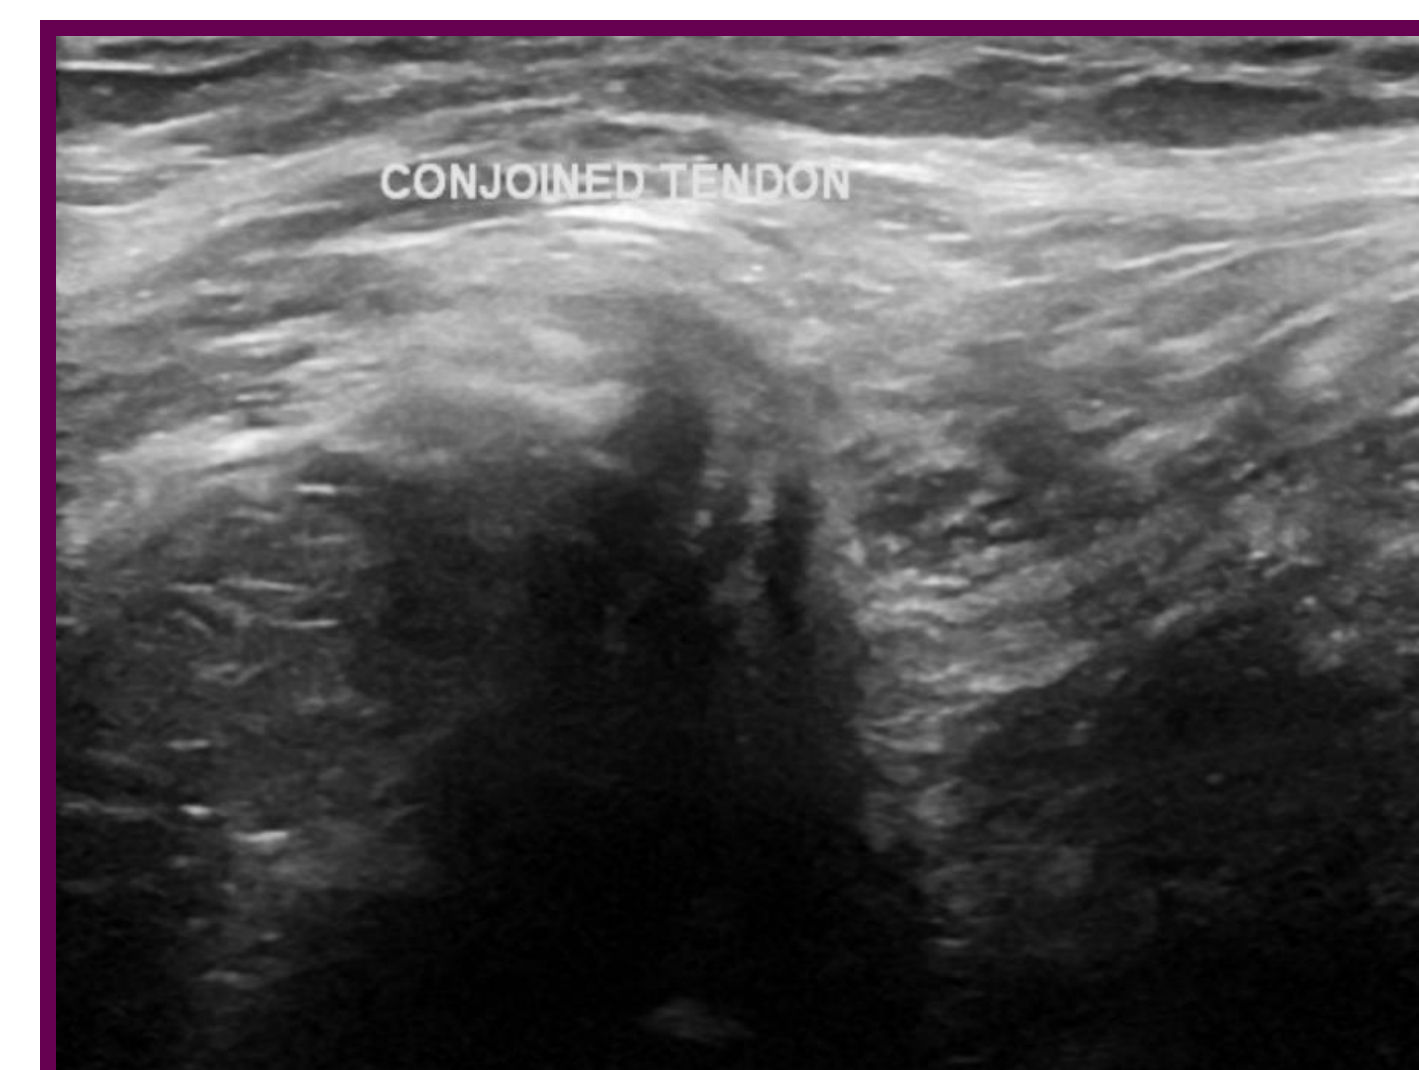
Ultrasound of right shoulder revealing conjoint tendon
